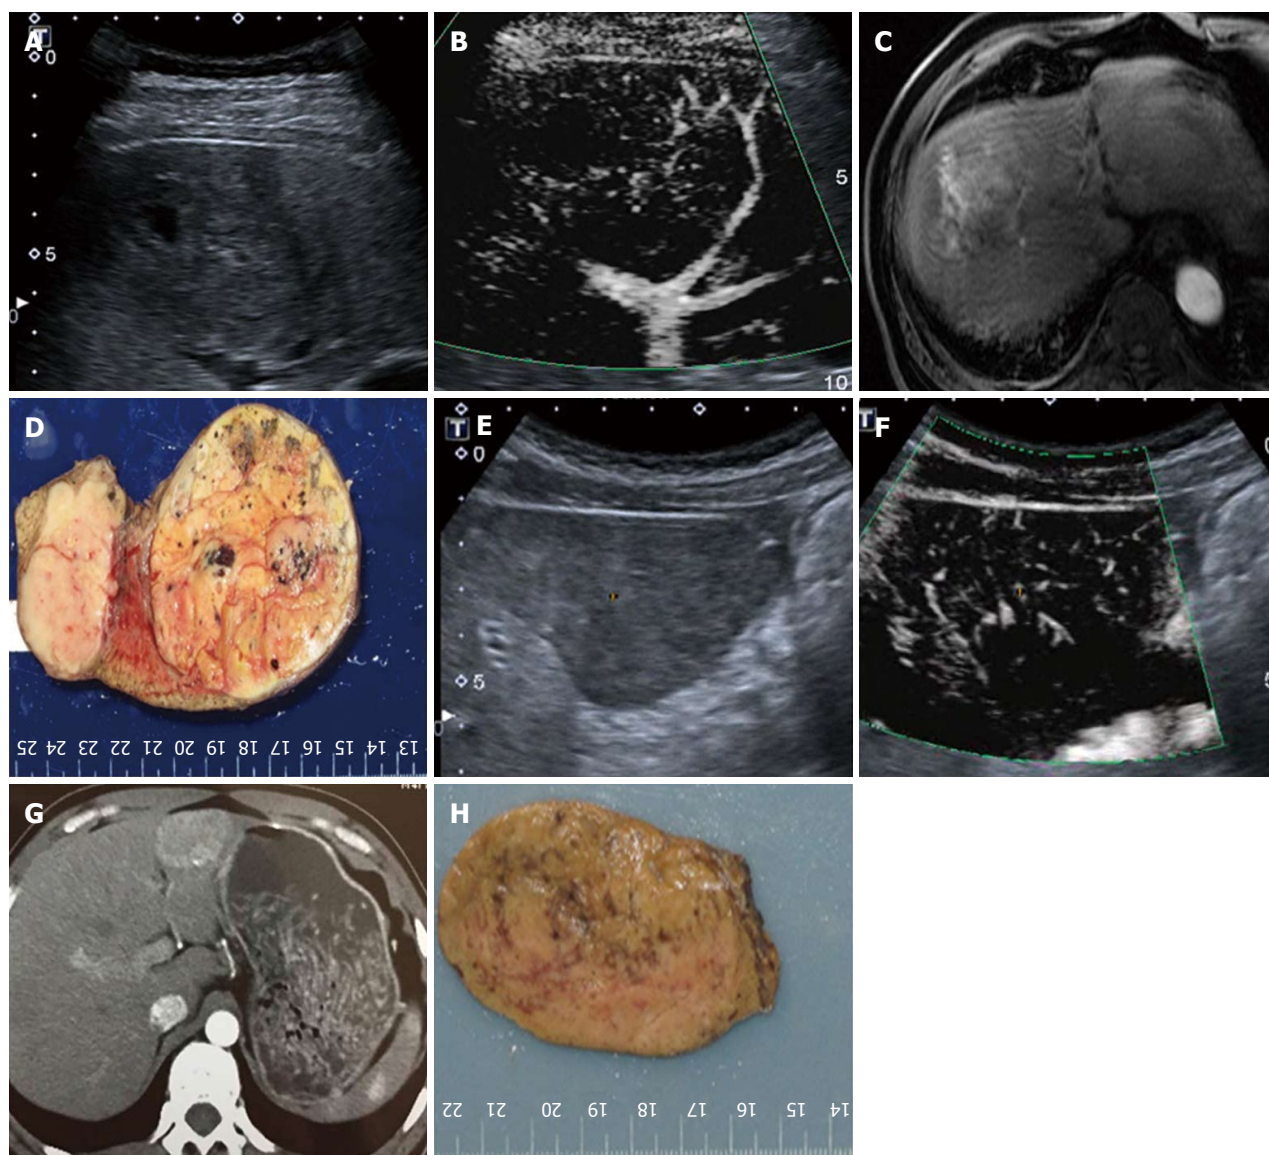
Diffuse honeycomb type (type IV). A-D: A 68-year-old male diagnosed with hepatic cellular carcinoma. A: A mixed-echo lesion with a relatively unclear margin was evident in the right liver lobe; B: SMI showed a diffuse honeycomb-distributed microvascular structure; C: Contrast-enhanced MRI showed diffuse enhancement of the lesion in the arterial phase; D: The pathology result showed that the inter-tumor blood vessels were distributed in a grid pattern resembling honeycombs. E-H: A 41-year-old male diagnosed with hepatic adenoma. E: A hypo-echo lesion with a clear margin was evident in the left liver lobe; F: SMI showed a diffuse honeycomb-distributed microvascular structure; G: Contrast-enhanced CT showed diffuse enhancement of the lesion in the arterial phase; H: The pathology result showed that the inter-tumor blood vessels were distributed in a grid pattern resembling honeycombs. SMI: Superb microvascular imaging.
